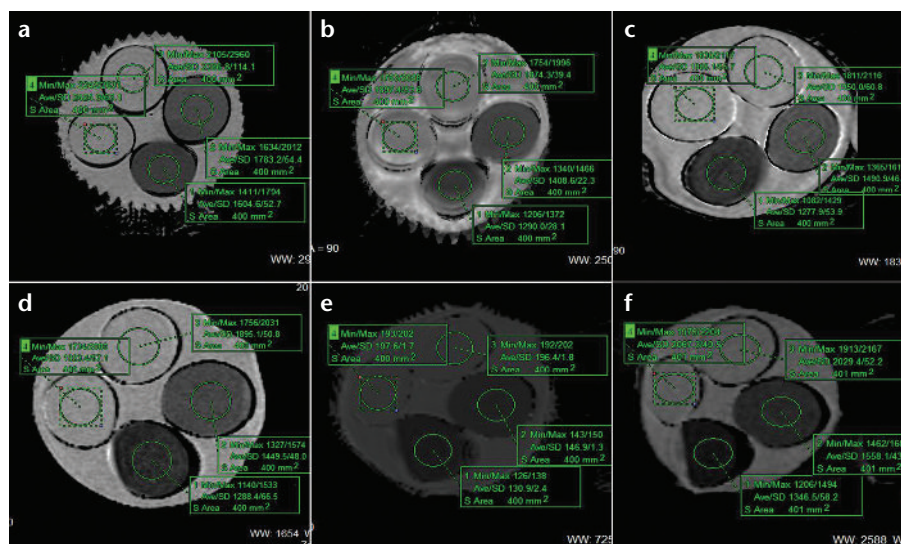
a–f. ADC maps from six different MRI scanners (a, Excelert Vantage, Toshiba Medical Systems; b, Signa, GE Healthcare; c, Gyroscan Intera, Philips Healthcare; d, Avanto, Siemens Medical Systems; e, Symphony, Siemens Medical Systems; f, Essenza, Siemens Medical Systems). ADC calculations were obtained from the workstation (Virtual Place Advance Plus, Aze).
